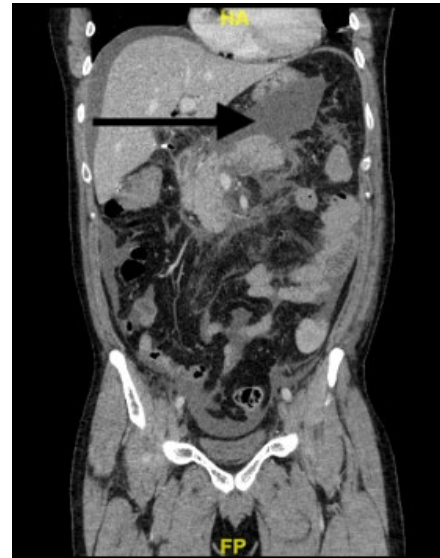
Abdominal CT scan shows pancreatitis and newly forming peripancreatic fluid.
